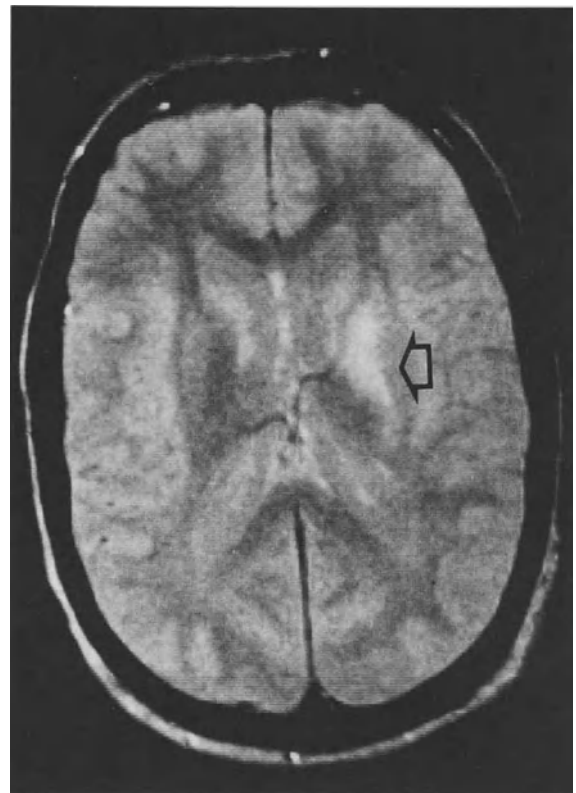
a, b. Substance loss and cystic defect at MRI. a T2-WI (*arrow*) shows cerebral toxoplasmosis. The lesion in the area of the left putamen led to a cystic substance loss. b T1-WI from an examination performed 2 years later (*arrow*) reveals the former lesion as an area of low signal intensity
